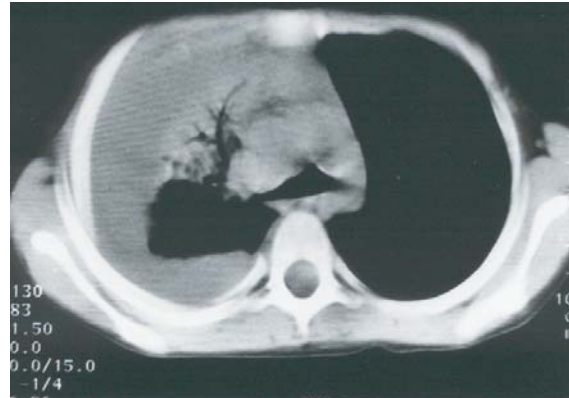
Chest computerized tomography (CT) scan at admission.
